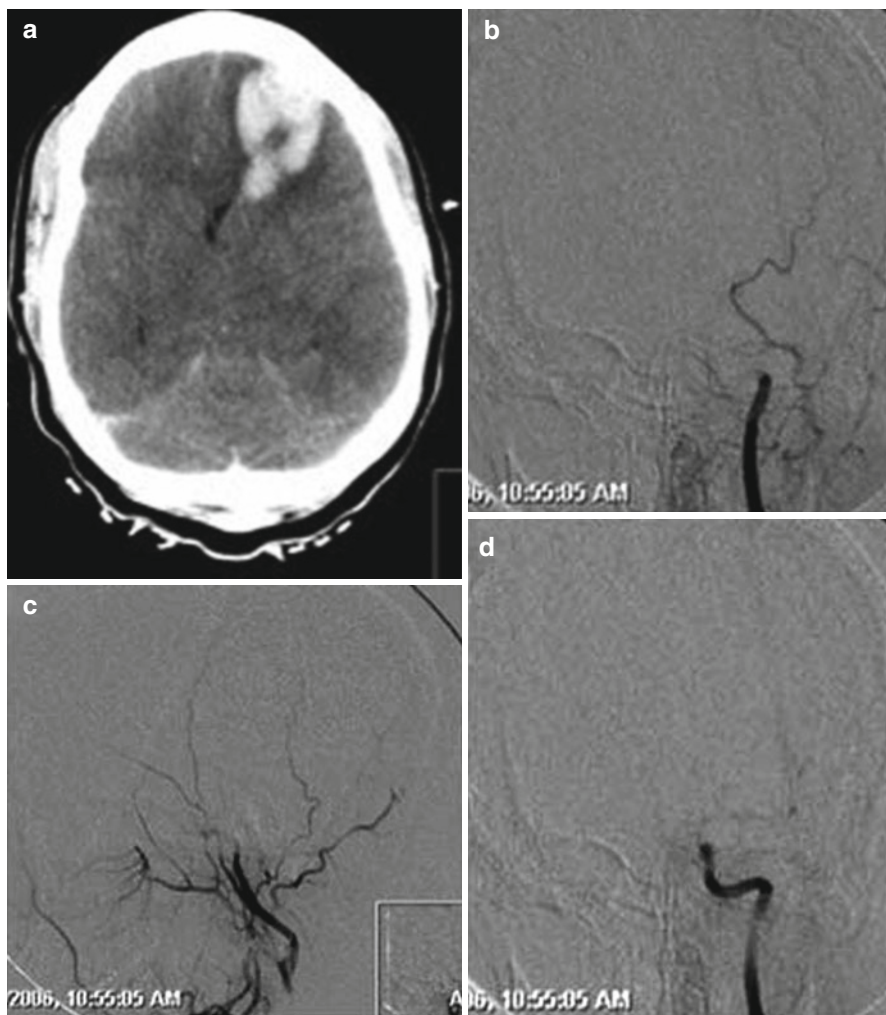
Non-contrast computed tomography scan of the head (a) in an anonymous young female who was found comatose and tested positive for multiple drugs with evidence of a space-occupying left frontal lobar hemorrhage and diffuse brain edema. Cerebral angiography was pursued to rule out an underlying vascular anomaly. Left common carotid artery injection demonstrated cessation of flow distal to the supraclinoid segment of the left internal carotid artery in frontal (b, arterial phase; d, late capillary phase) and lateral plane (c, arterial phase; e, late capillary phase) leading to contrast stasis in the extradural segments of the left internal carotid artery. The left external carotid artery branches well opacified. Circulatory arrest at the foramen magnum was confirmed for the left vertebral artery (f, arterial phase; g, capillary phase) given the lack of opacification of any intradural segment of the left vertebral artery (Images courtesy of Darren B. Orbach, Interventional Neuroradiology, Boston Children's Hospital)
